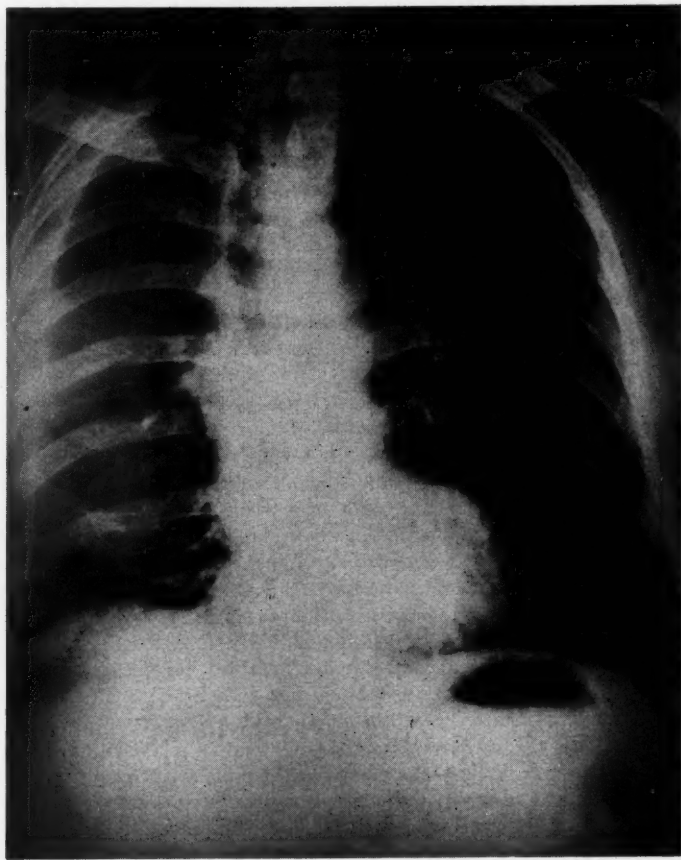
Chest roentgenogram, 4-17-53, showing markedly thickened pleura. Sputum was positive. Cavity was demonstrated in superior segment of right lower lobe on right lateral tomograms, correlating with the findings noted at right "hilum" region on this film. Original treatment SM-PAS had been started 12-7-52. Right upper lobe free of demonstrable disease.
